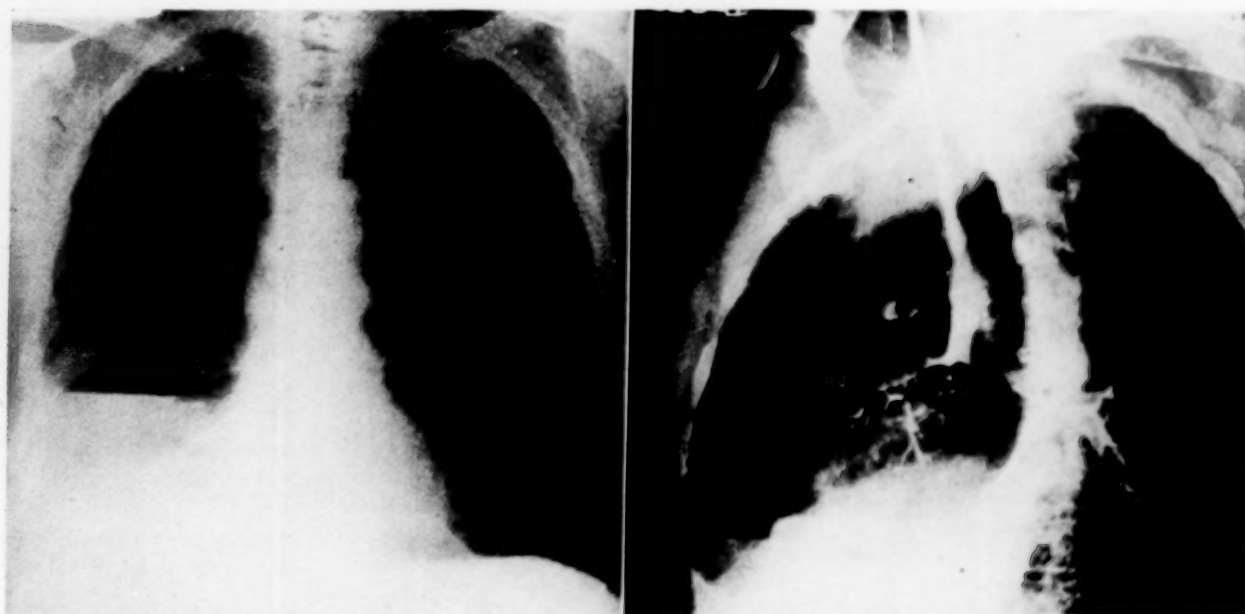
Case II. Preoperative chest roentgenogram and bronchogram. An empyema cavity with an air fluid level is seen on the right. The bronchogram demonstrates complete occlusion of the intermediate bronchus.
